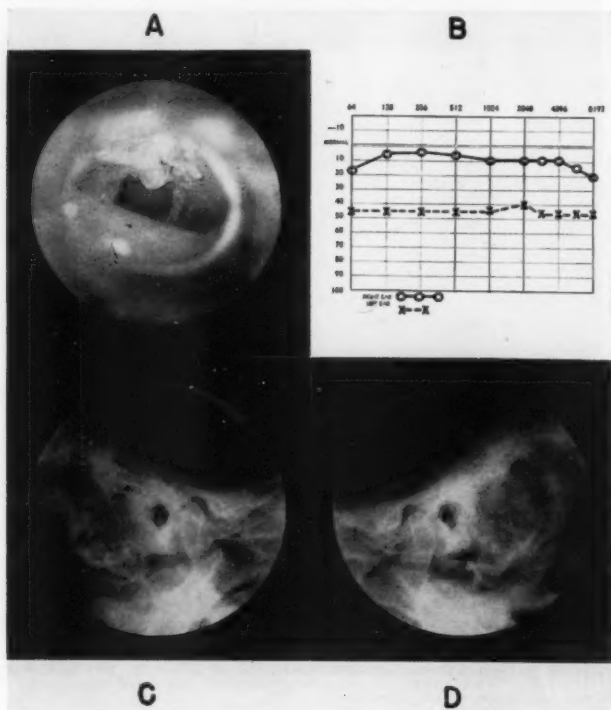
(A) Appearance of the left drum membrane of a 50-year-old male with discharge from the ear for over two years. The ears had appeared normal when seen previously for tuberculosis of the larynx. (B) Audiogram, made after the ear had been discharging for two years. (C) The right and (D) the left mastoid X-ray. Both are well pneumatized; the left has increased density.
